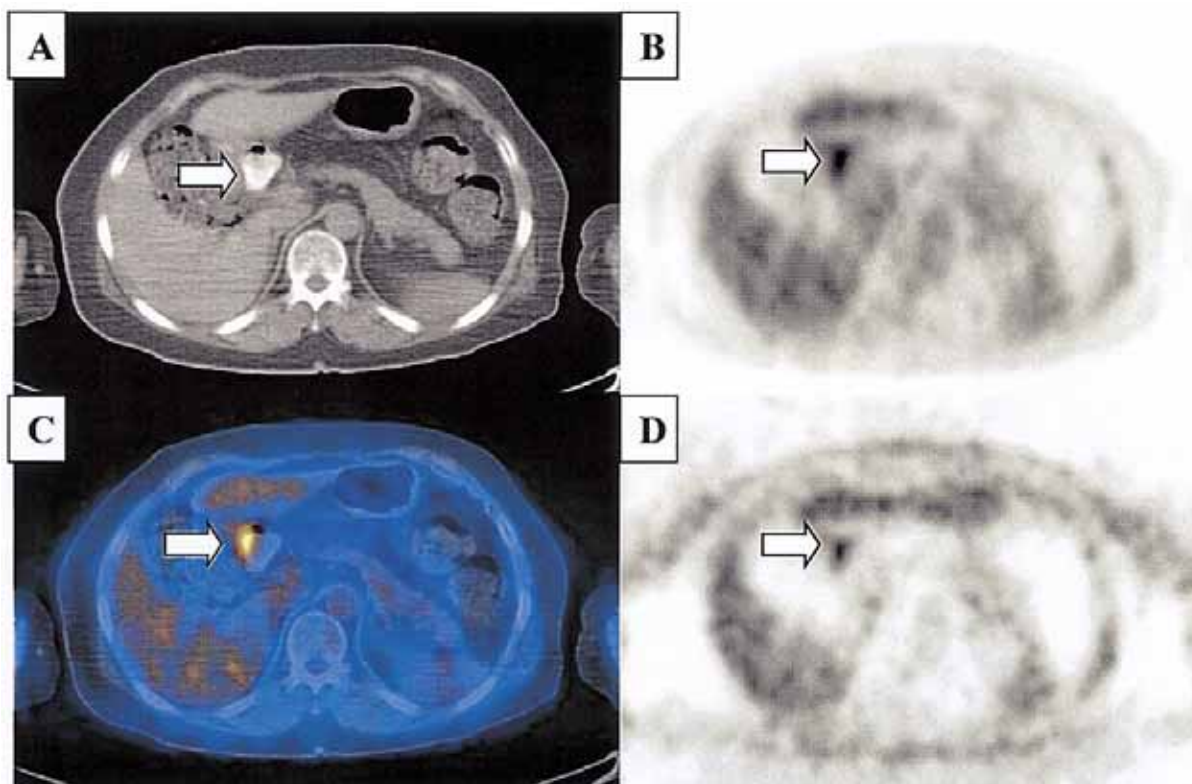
The presence of oral contrast is observed in small bowel on CT image (Fig 1A, arrow) and there is apparently focal increased glucose metabolism on corrected PET image (Fig 1B, arrow). On fused PET/CT image, this focal FDG uptake is coexisted with oral contrast (Fig 1C, arrow). Non-attenuation corrected PET image demonstrates also increased FDG uptake in same area (Fig 1D, arrow) and we can conclude this uptake is not due to contrast-induced artifact.
